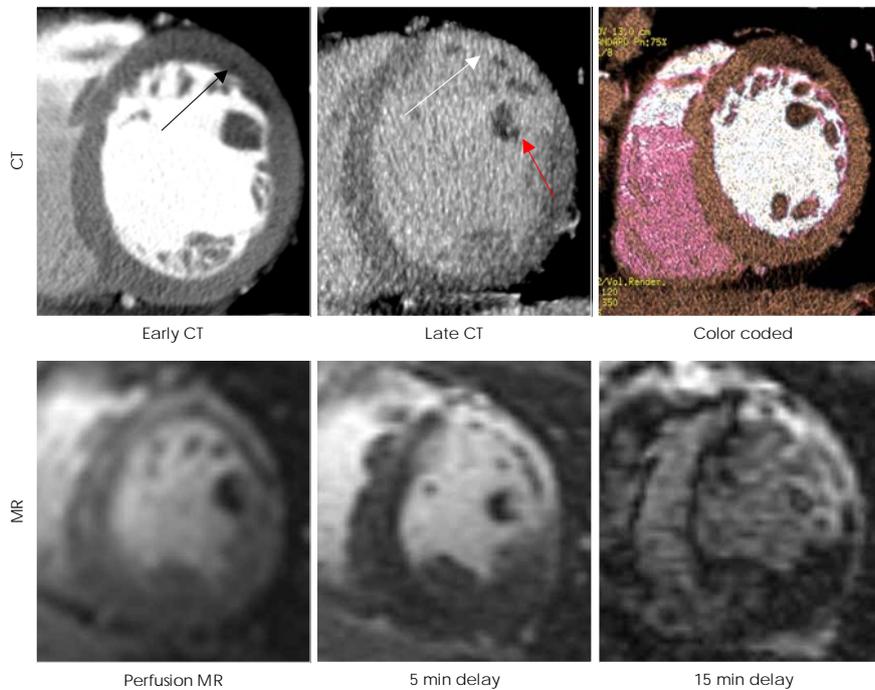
In this acute MI case, the findings on the early- and late-phase CT images (perfusion defect on the early phase (black arrow) and delayed hyperenhancement (white arrow) and persistent perfusion defect (red arrow) in the papillary muscle) were well correlated with those findings on the perfusion and delayed MR images and on color-coded CT images, and so they helped to assess the infarcted area. CT: computed tomography, MI: myocardial infarcted, MR: magnets resonance imaging.
